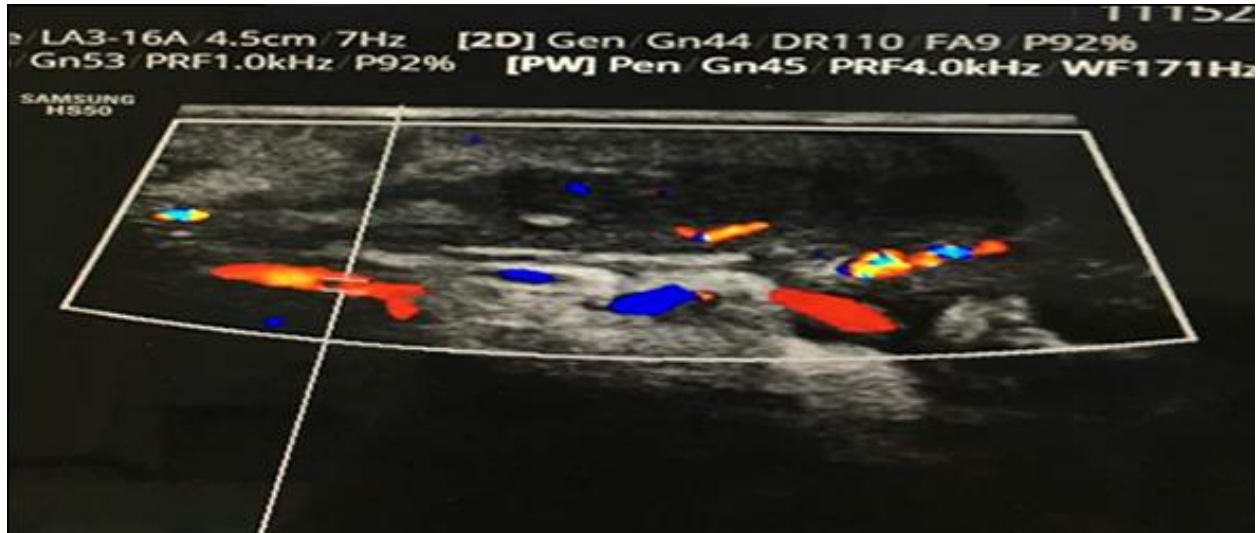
Ultrasound performed on day 6 demonstrated less echogenicity in the previous engorged and dilated pampiniform plexus. It showed good doppler signal and features consistent with resolution of left pampiniform plexus thrombosis.
